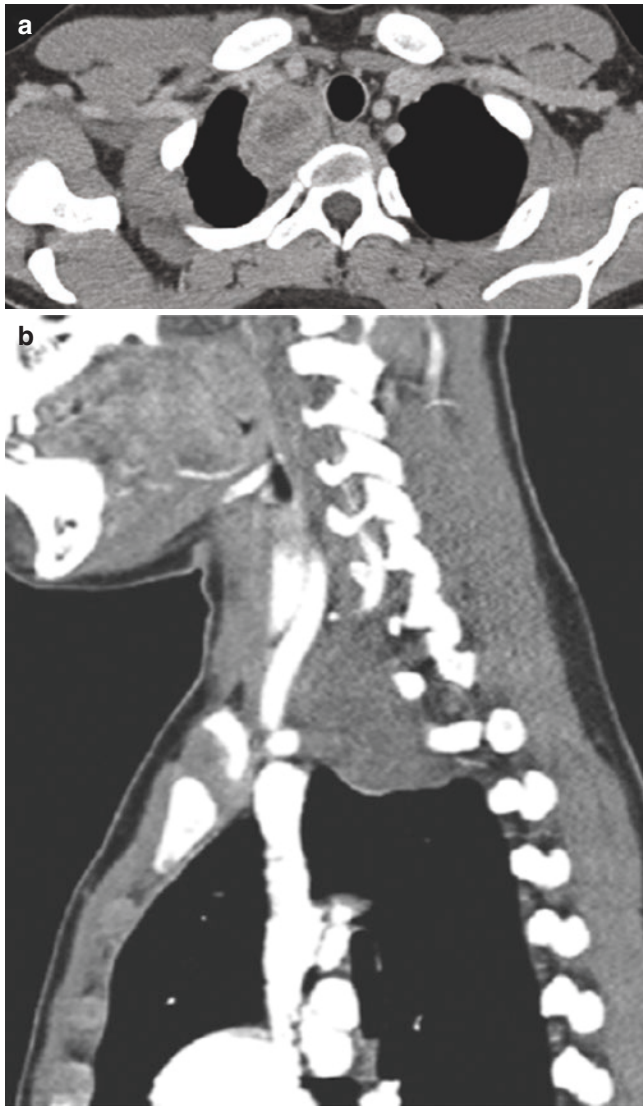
A 17-year-old boy who presented with neurofibromatosis type 1 and new Horner's syndrome. (a) Enhanced axial CT image demonstrates a heterogeneously enhancing mass in the mediastinum adjacent to the right lung apex which had grown substantially since a prior CT, consistent with a MPNST. (b) Sagittal-enhanced CT image confirms that this mass is in the posterior mediastinum
